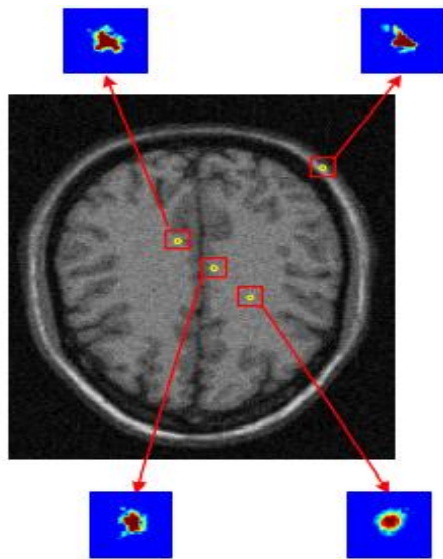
Input MRI Image.
